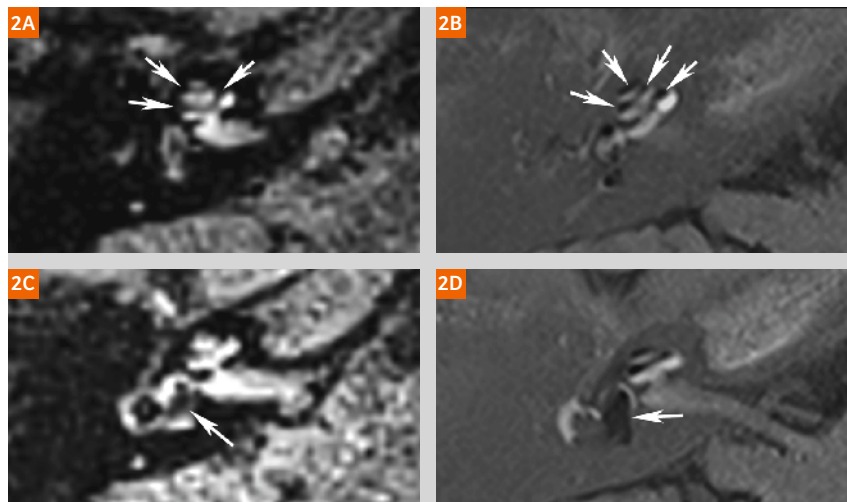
3D SPACE FLAIR (2A, C) and 3D real IR (2B, D) imaging of the right ear of a patient with Ménière's disease. The presence of endolymphatic hydrops (marked by arrows) can be visualized within the cochlea (2A and B) and within the vestibule (2C and D). While the presence of endolymphatic hydrops within the cochlea is visible on the 3D SPACE FLAIR image (2A), the 3D real IR image clearly shows a severe presence at each turn of the cochlea (2B). The presence of vestibular endolymphatic hydrops is visible as an enlarged area of low signal in the patient's right vestibule on the 3D SPACE FLAIR (2C) and 3D real IR (2D). Note that in the 3D real IR image, there is clear differentiation between the endolymphatic space (low signal), the perilymphatic space (high signal) and the surrounding bone (intermediate signal) while it is more difficult to differentiate between the endolymphatic space from the surrounding low-signal bone in the 3D SPACE FLAIR image.
